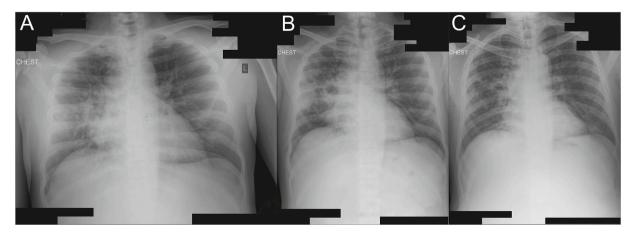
(A) Chest X-ray on day 1, oedema pulmonum and bilateral consolidation (atypical virus), (B) Chest X-ray on day 6, pneumonia with increasing vesicular, and (C) Chest X-ray on day 11, less lession compared to previous chest x-ray.
